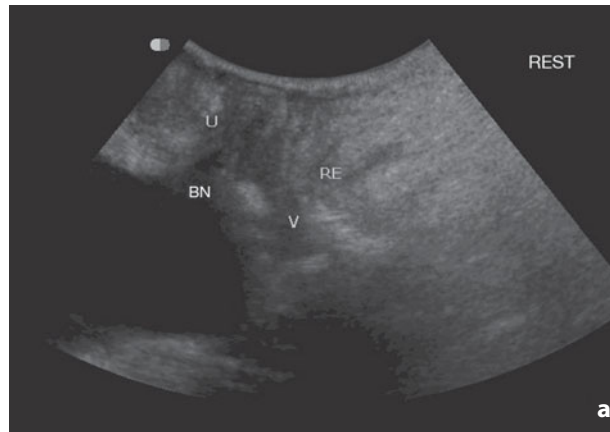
Introitus ultrasonography. a Median sagittal scan at rest. The relations between the pelvic organs are normal. b Under stress a descent of the bladder base is visible, which reaches the perineal plane, with the urethra in near horizontal position (cystocele). *BN*, bladder neck; *U*, urethra; *V*, vagina; *RE*, rectum
